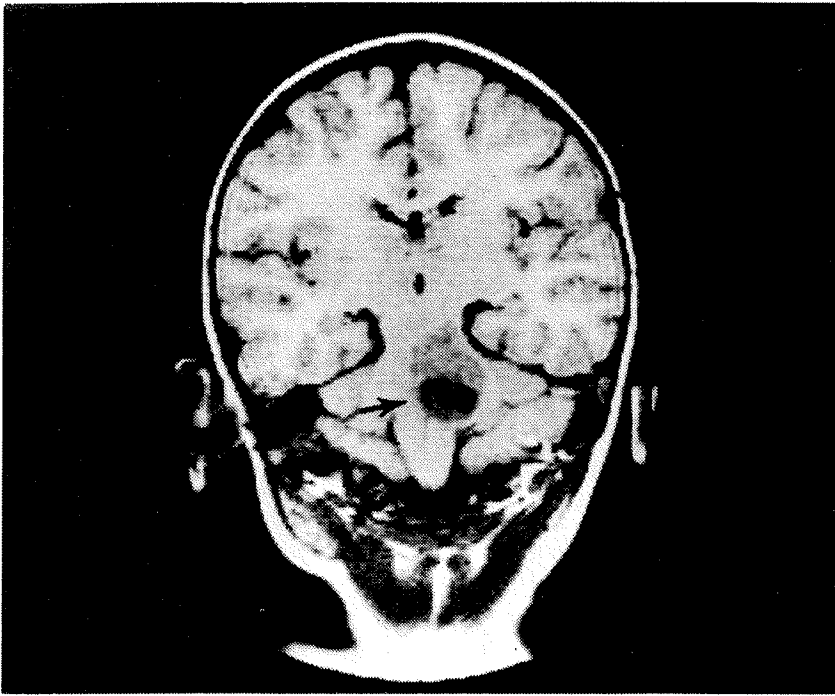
Partially Cystic Pontine Glioma. Coronal MR image shows asymmetrically expanded pons with cystic component (arrow).
